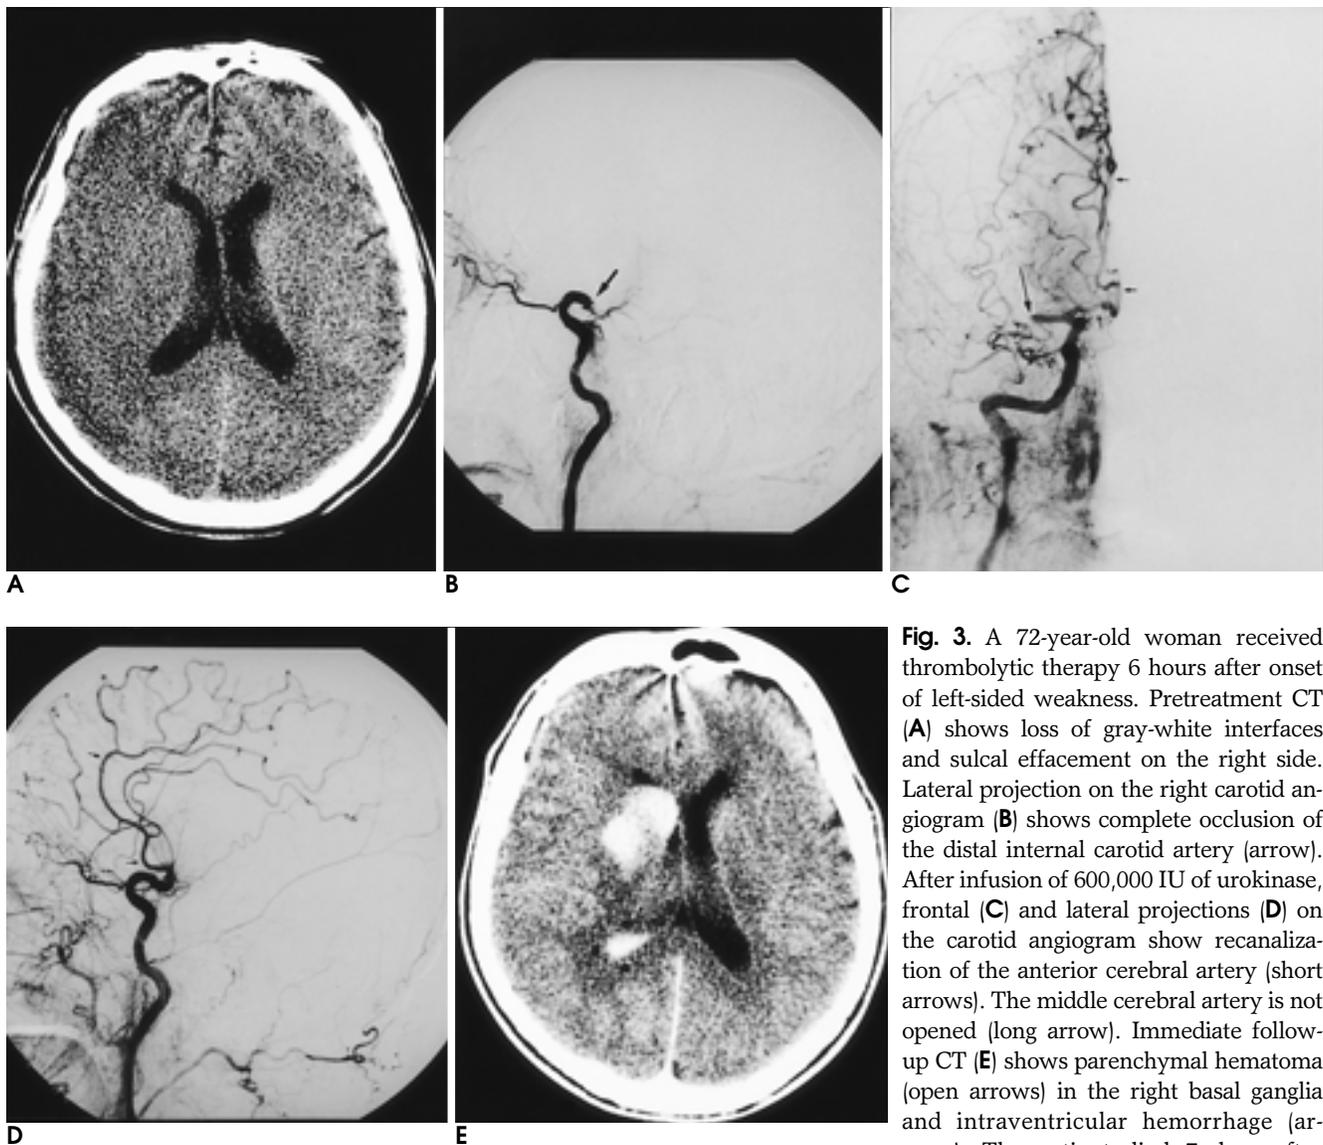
A 72-year-old woman received thrombolytic therapy 6 hours after onset of left-sided weakness. Pretreatment CT (A) shows loss of gray-white interfaces and sulcal effacement on the right side. Lateral projection on the right carotid angiogram (B) shows complete occlusion of the distal internal carotid artery (arrow). After infusion of 600,000 IU of urokinase, frontal (C) and lateral projections (D) on the carotid angiogram show recanalization of the anterior cerebral artery (short arrows). The middle cerebral artery is not opened (long arrow). Immediate follow-up CT (E) shows parenchymal hematoma (open arrows) in the right basal ganglia and intraventricular hemorrhage (arrows). The patient died 7 days after thrombolytic therapy.
